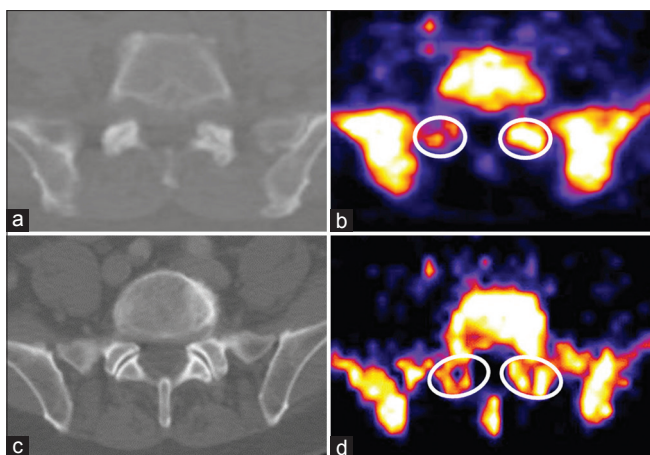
Discrepant results between CT Pathria grade of facet arthropathy and NaF PET uptake with hybrid PET-CT imaging.
